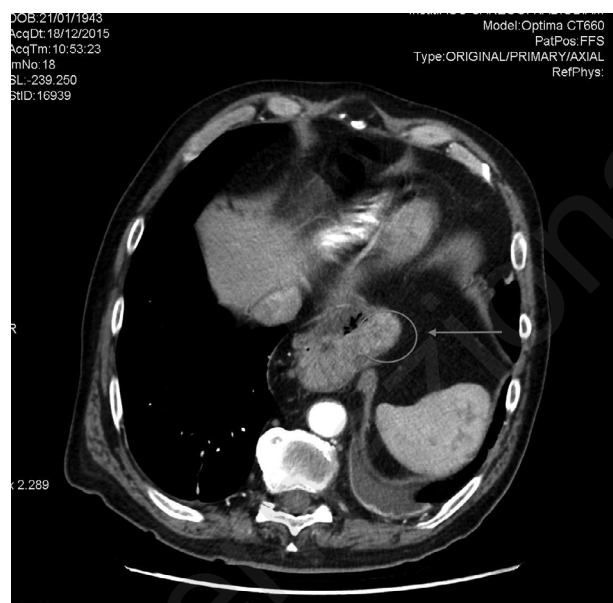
CT-scan image showing the Cameron ulcer at the diaphragmatic impression with a para-esophageal hiatal hernia. In the image, the bleeding ulcer appears hyperdense compared to the gastric wall.
